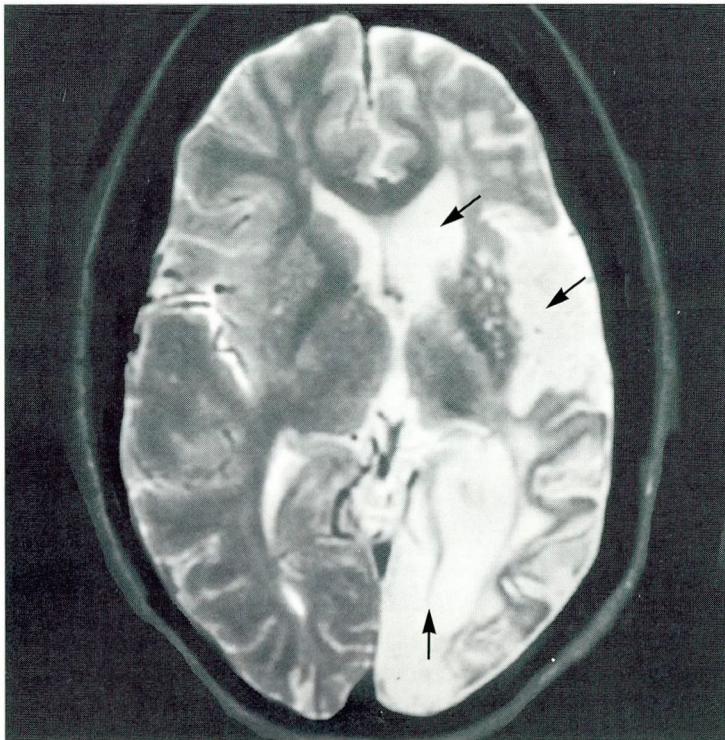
Magnetic resonance imaging of the brain of a patient with sickle cell anemia shows extensive encephalomalacia with secondary enlargement of the left lateral ventricle due to old infarcts in the distribution of the left middle and left posterior cerebral arteries (arrows).
